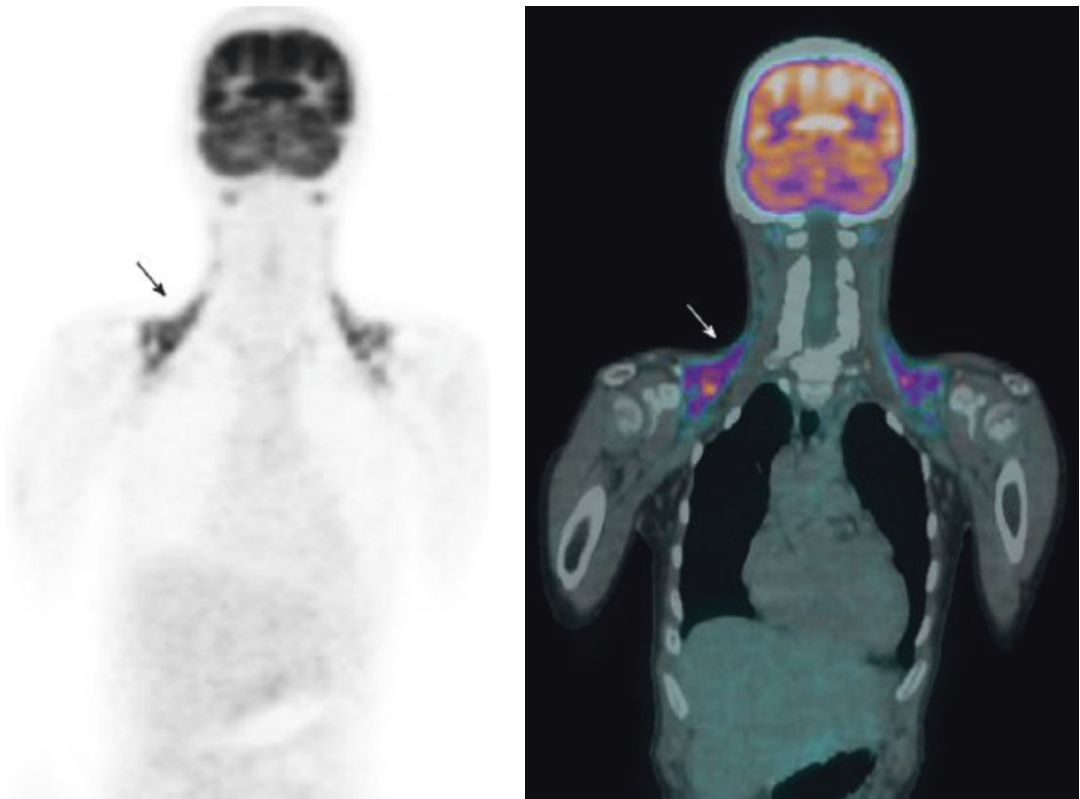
(a–g) FDG-PET/CT initial staging study
